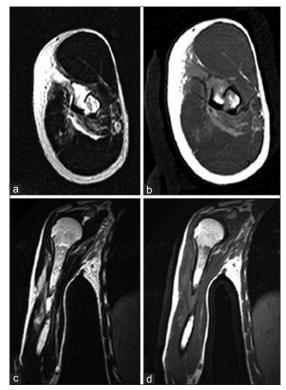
Preoperative magnetic resonance imaging. (a) Transverse T2-weighted image showing high signal intensity on shaft of humerus. (b) Transverse T1-weighted image showing intermediated signal intensity on shaft of humerus. (c) Coronal T2-weighted image showing heterogeneity osteolytic lesion on fracture site. (d) Coronal T1-weighted image intermediated signal intensity on fracture site
